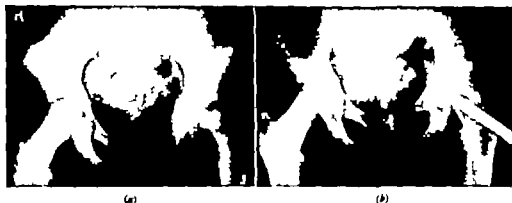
A series of radiographs to demonstrate treatment by cervical wedge osteotomy and nailing in a girl aged 12 in 1952. (a) The original lesion of the *left* hip. (b) The condition 9 months later 11/52.
